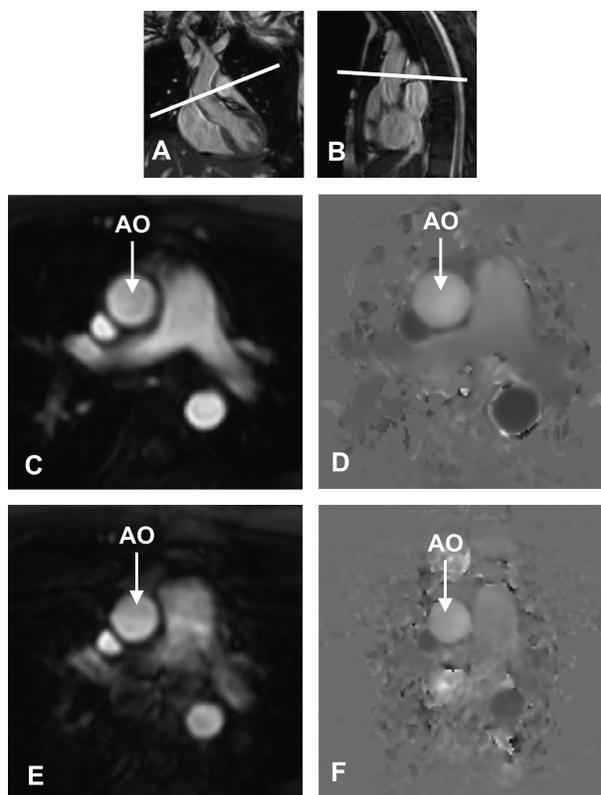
PC-MRI for determination of flow rate in the ascending aorta. Upper row: Plan scans (panel A, frontal/coronal view, and panel B, sagittal view) for flow quantification in the ascending aorta used steady-state free-precessing gradient echo (field of view 530 mm, matrix 125*256, 8-mm slice thickness, echotime 2.4 ms, repetition time 1.2 ms, flip angle 60°). Middle row: Standard phase-contrast MRI (without SENSE), used as reference method. In phase images (panel D), flow information is encoded through-plane for each pixel in the cross-sectional area. Panel C is the corresponding magnitude image displaying anatomical information (AO = ascending aorta, arrows, panels C and D). Bottom row: Magnitude (panel E) and phase images (panel F) by PC-MRI with SENSE reduction-factor 2 in the same patient (scan parameters, see Table 1). Please note the discrete reduction of signal-to-noise ratio in the magnitude images (panel E) compared with standard/reference PC-MRI (panel C).
